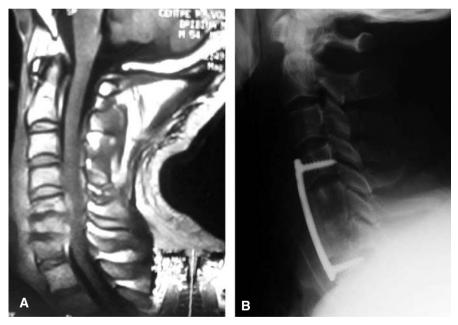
A T1-weighted sagittal MRI. Cervical spine TB involving two disks (C4-C5 and C5-C6) and three vertebral bodies (C5, C6, and C7). B Postoperative cervical spine X-ray showing C5, C6, and C7 partial corporectomy with iliac bone graft and anterior osteosynthesis with plate
